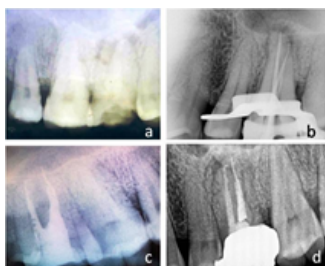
(a) Pre operative Intraoral Periapical radiograph
